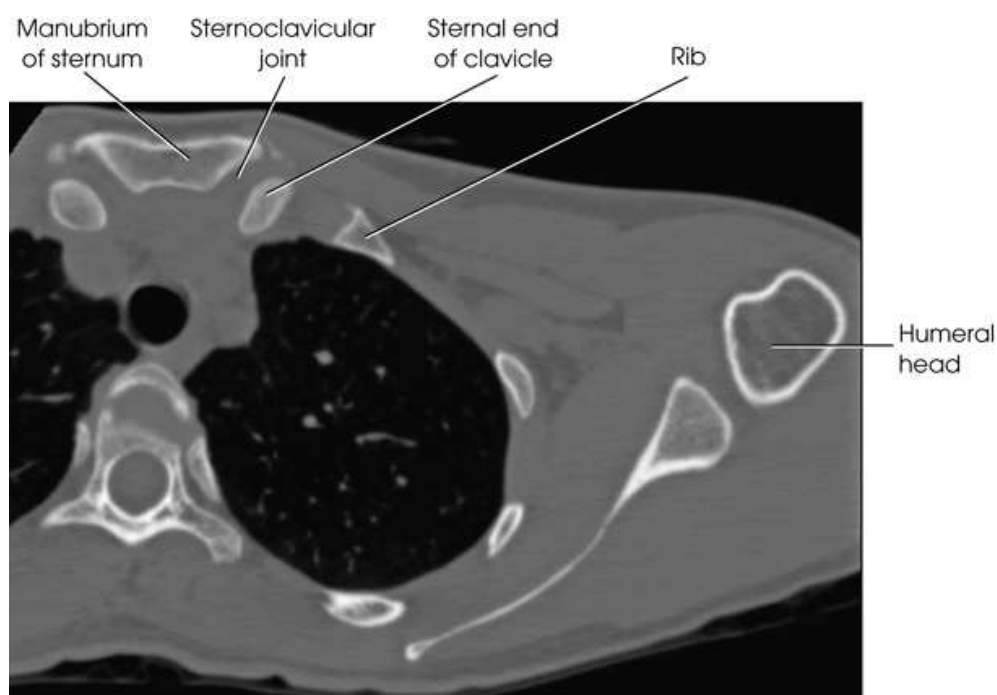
Axial CT scan of shoulder showing relationship of anatomy. Note 45- to 60-degree angle of scapula.
